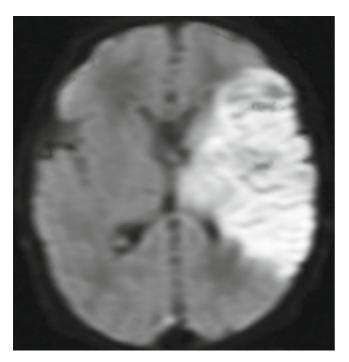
DW MRI: focal large artery stroke (MCA) associated with *Listeria meningitis* in a term infant
